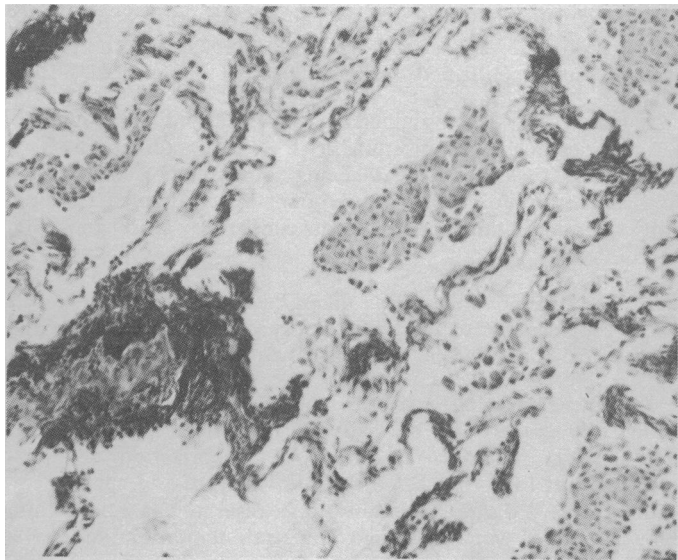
Case 2. Lung biopsy in a man with dyspnoea due to a gas transfer defect, whose chest radiograph was normal, showing many large mononuclear cells in alveoli and patchy fibrotic thickening of alveolar walls. (H. & v.G. $\times 130$.)
